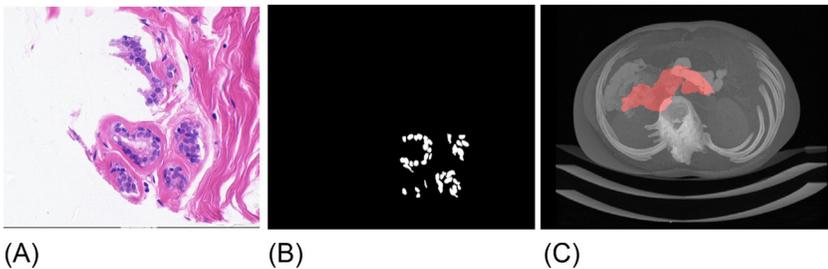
(A) Breast cancer cell original (B) segmentation. (C) Pancreas segmentation from CT scans.
